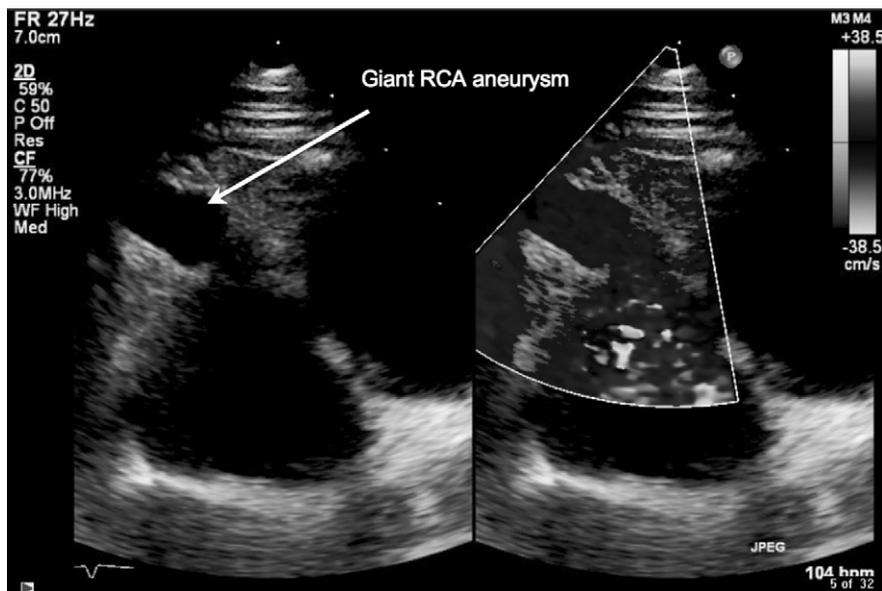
Parasternal short axis echocardiographic image showing a giant right coronary artery (RCA) aneurysm.
